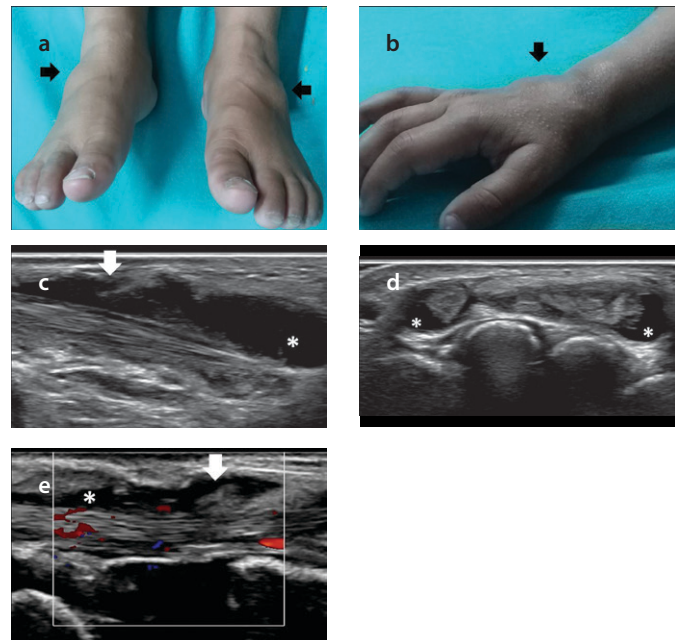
a-e. Clinical photographs and ultrasound images in a child with Blau syndrome. Boggy swellings (black arrows) over the ankle joints (a). Boggy swelling (black arrow) and micropapular rash over the dorsum of the right hand and wrist (b). Gray-scale synovitis of the tibialis anterior tendon (dorsal medial longitudinal scan) (c). Gray-scale synovitis of the extensor tendons of hand (dorsal transverse scan) (d). Gray-scale synovitis of one of the extensor digitorum tendons (dorsal longitudinal scan), with color Doppler reflecting increased blood flow (indicative of inflammation) (e). White arrows: synovial proliferation (hypoechoic frond-like projections); Asterisks: abnormal fluid accumulation (anechoic areas) (c-e).
